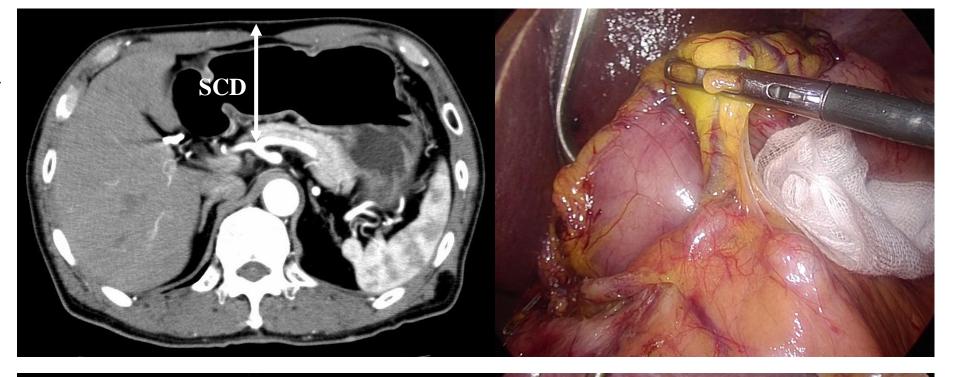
Findings from enhanced computed tomography scans and the gastropancreatic fold in thin (A) and obese patients (B).
